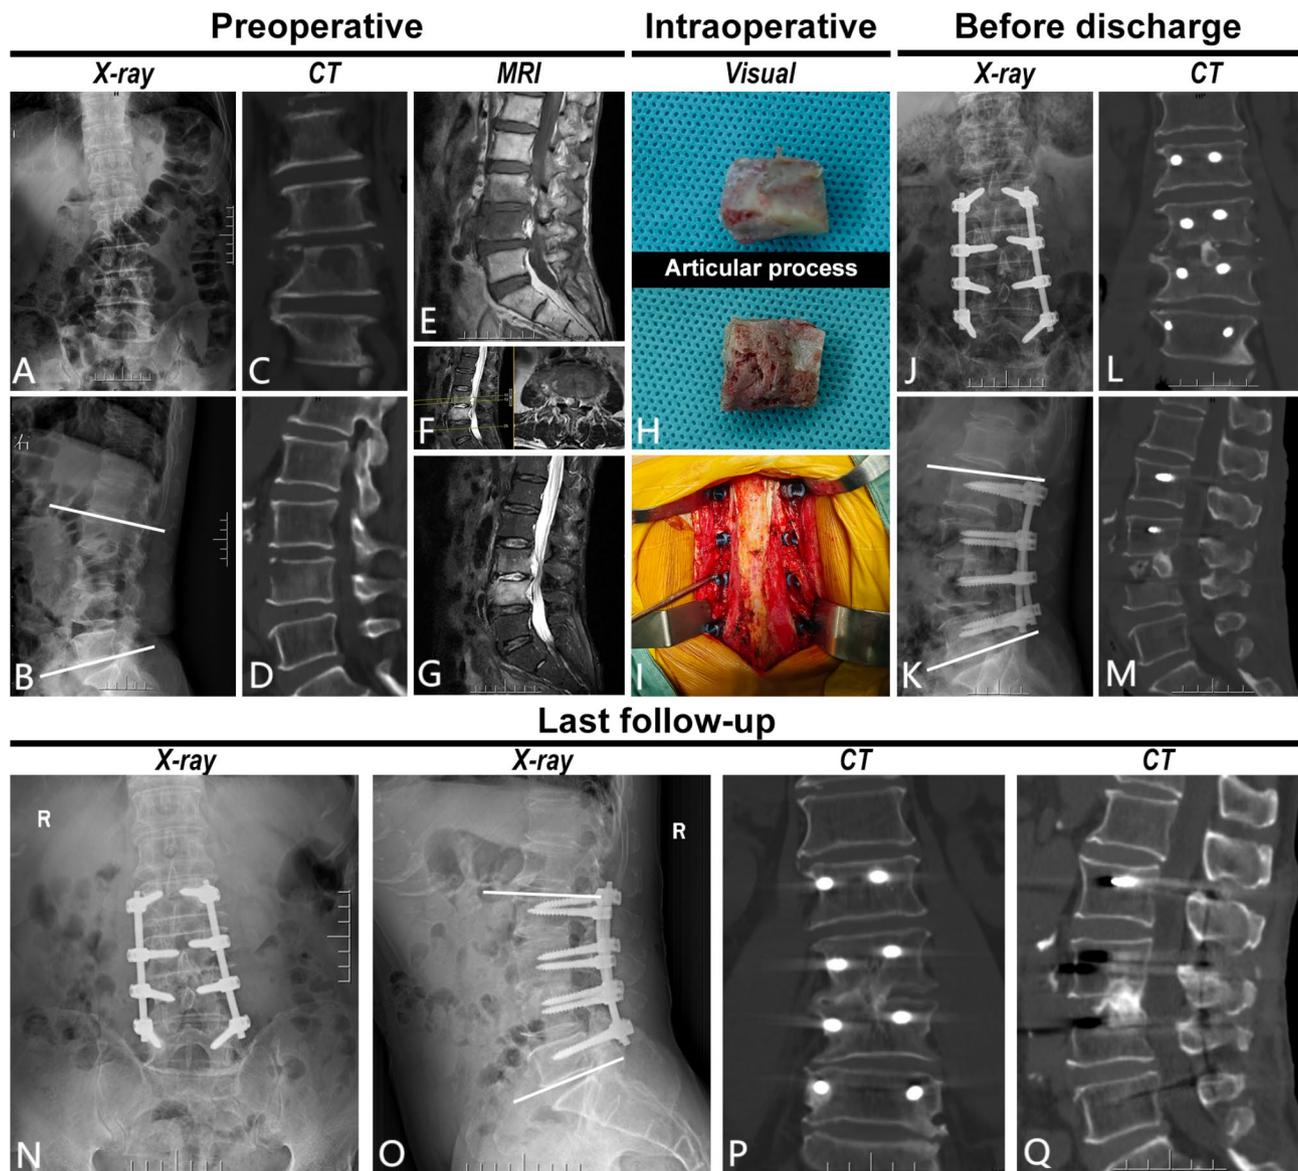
A 58 years old male with L₃/L₄ suppurative spondylitis after a 2 months history of intermittent back pain and numbness in both lower limbs. A-D preoperative X-ray, CT showed L₃/L₄ vertebral body and endplate destruction. E-G preoperative MRI showed diffuse abnormal signals of L₃/L₄ vertebra and intervertebral disc, abscess of lumbar major muscle. H, I intraoperative image showed internal fixation through multifidus and longissimus interspaces and articular process strutting bone grafting. J-M X-ray and CT showed position of internal fixation and bone graft were good, before discharge. N-Q X-ray and CT indicated satisfactory fusion of bone graft and good location of internal fixation at 18 months post-operation
